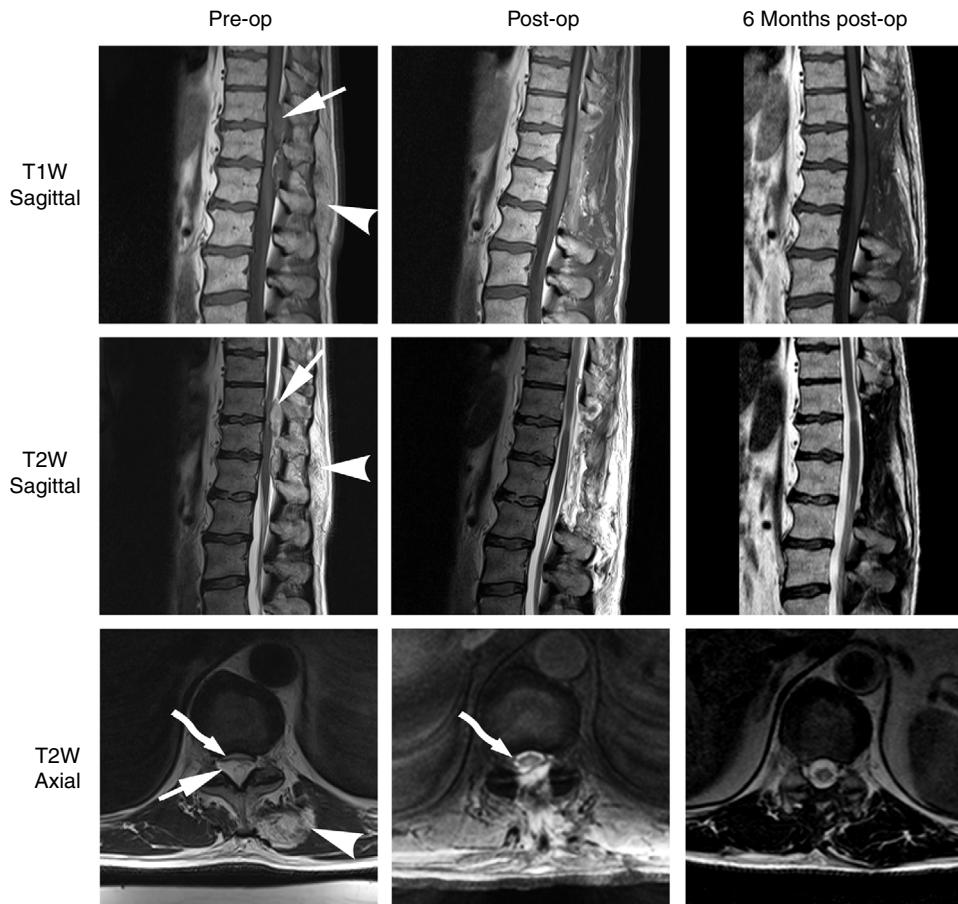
MRI of the thoracolumbar area (left column) showing an epidural mass on T11-L1 levels that was hypointense on T1W and iso- to hyperintense on T2W (arrow) and caused significant compression of the spinal cord (curved arrow), as well as an extra-canicular part that gave inhomogeneous signal with hypointense and hyperintense areas on T1W and T2W MRI (arrowhead). MRI on the 4th postoperative day (middle column) and 6 months later (right column), demonstrated the complete decompression of the spinal cord. All axial images were taken at the level of T11-T12 intervertebral disk. All images were taken in turbo spin echo sequence, except for the postoperative axial that was taken in gradient echo 2-D.
